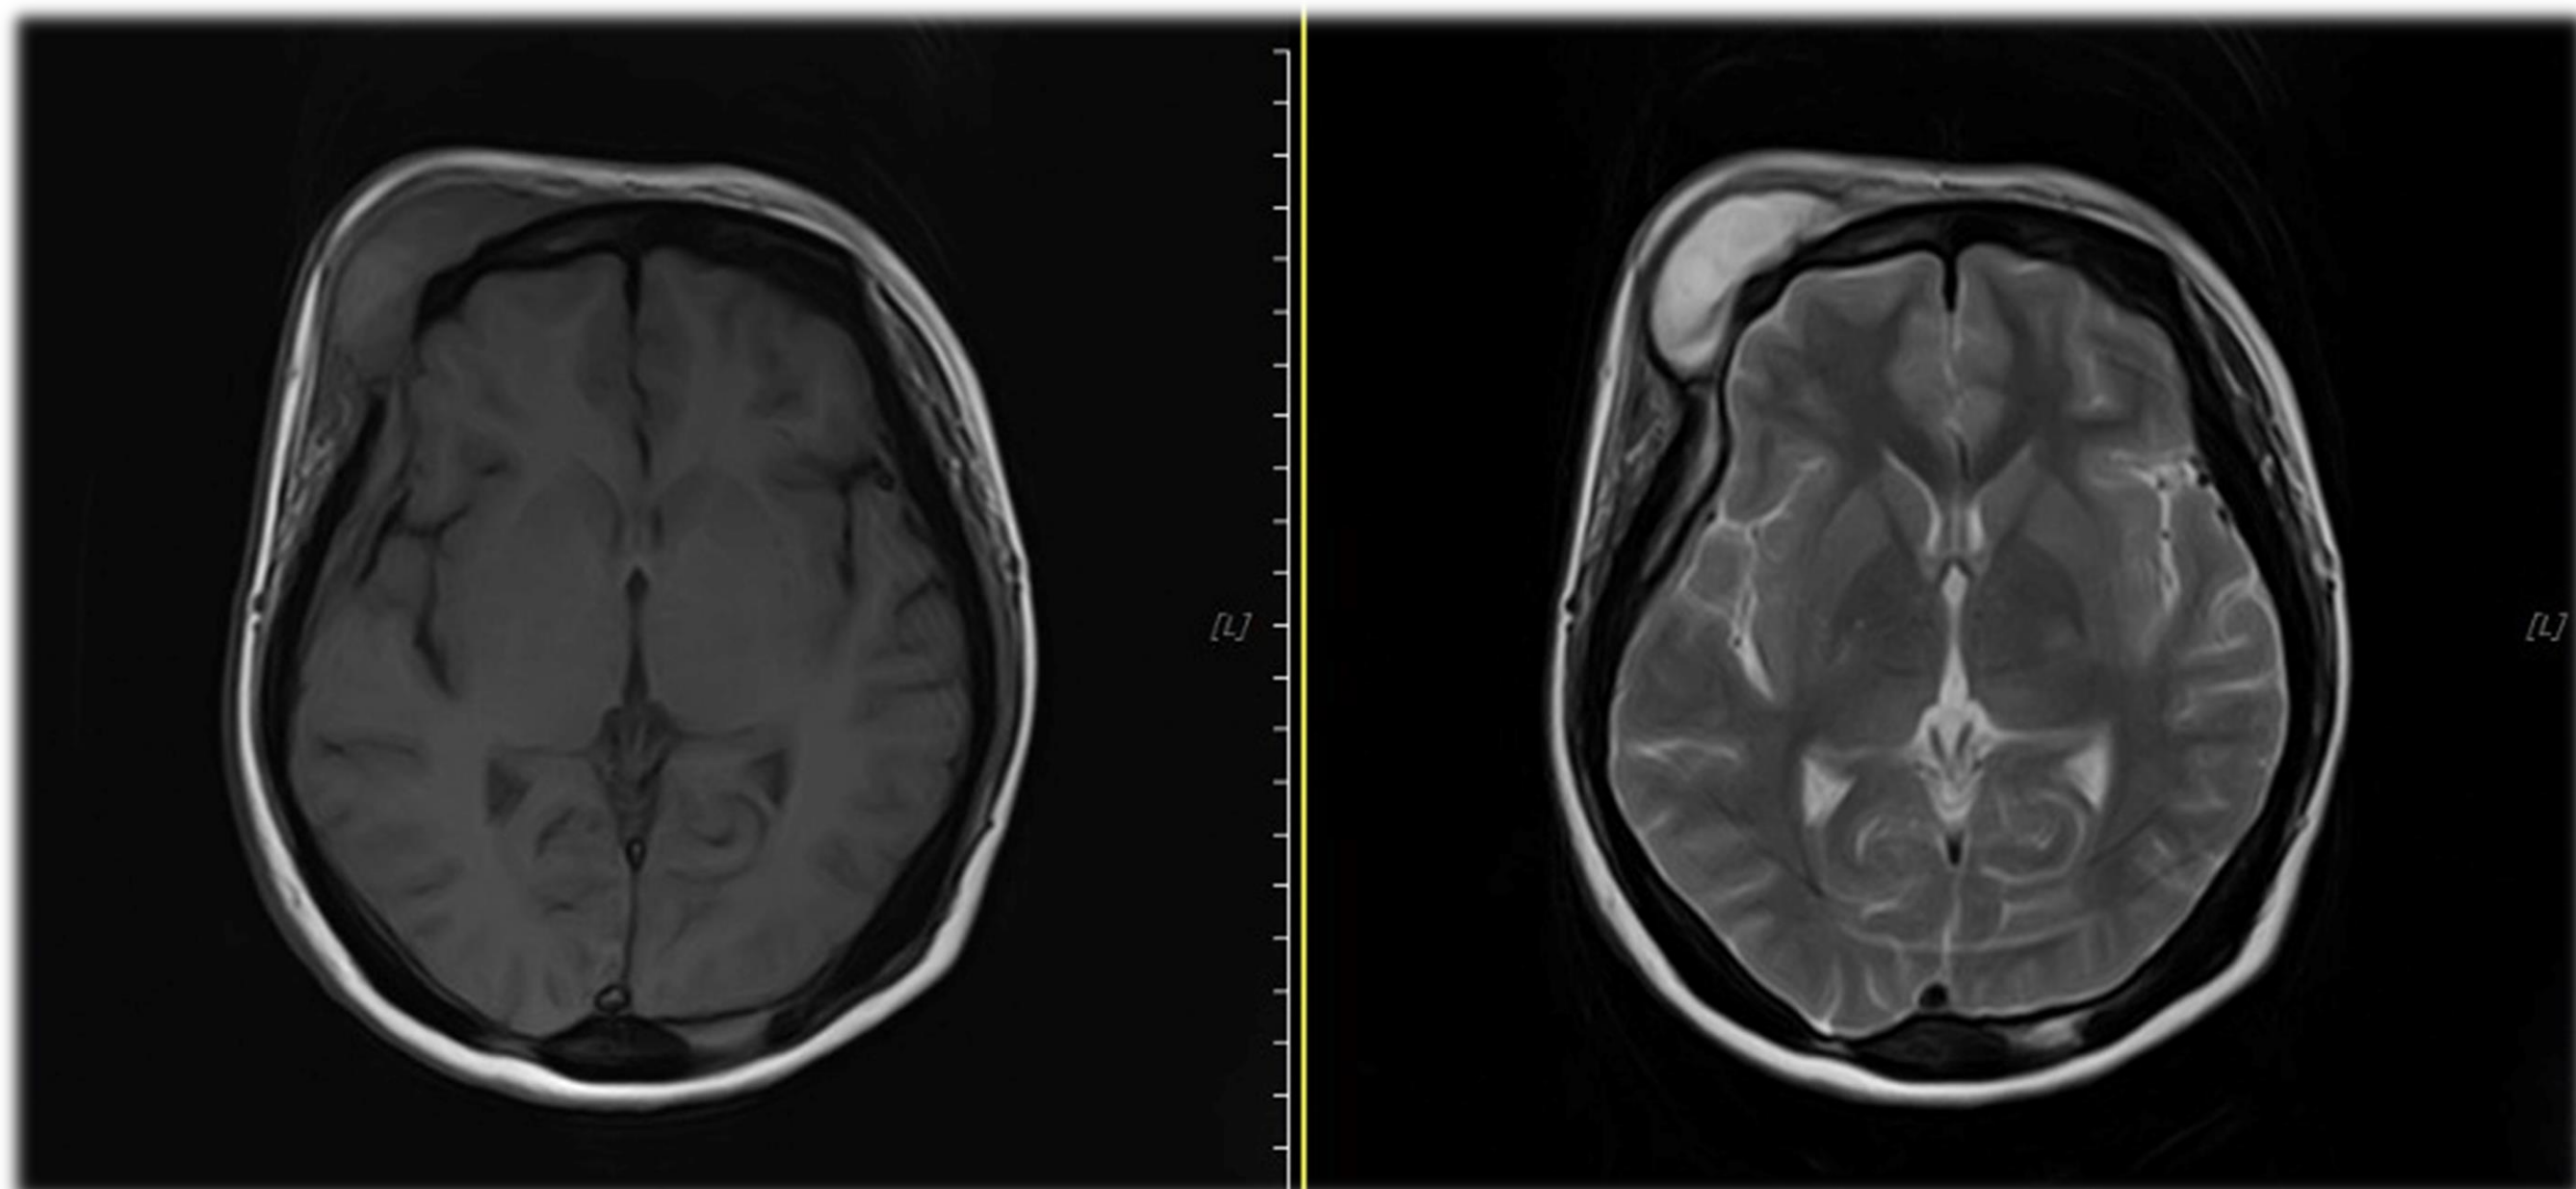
Lesion shows isointense on T1WI, and hyperintense on T2WI/FLAIR. The underlying right frontal bone underneath the collection is eroded with periosteal changes. Intracranially, there is a peripherally enhancing area seen at the right frontal extra-axial region with adjacent dural thickening.
